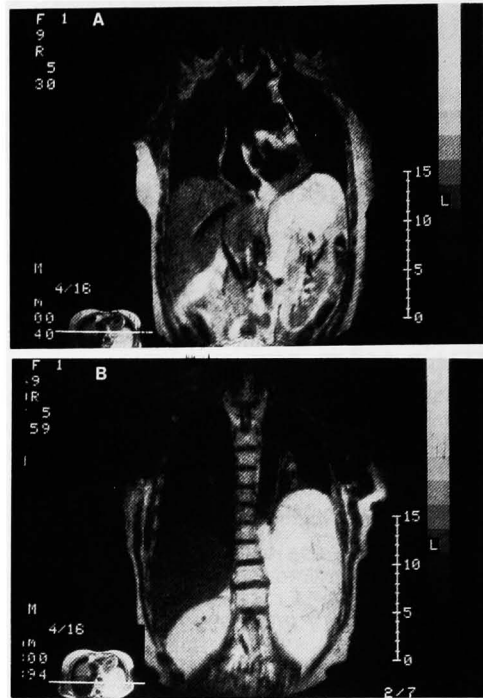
In coronal view of MRI, a sheetlike growth emerging from the upper pole of the left kidney and projecting posteriorly is revealed in T<sub>1</sub> weighted imaging.
